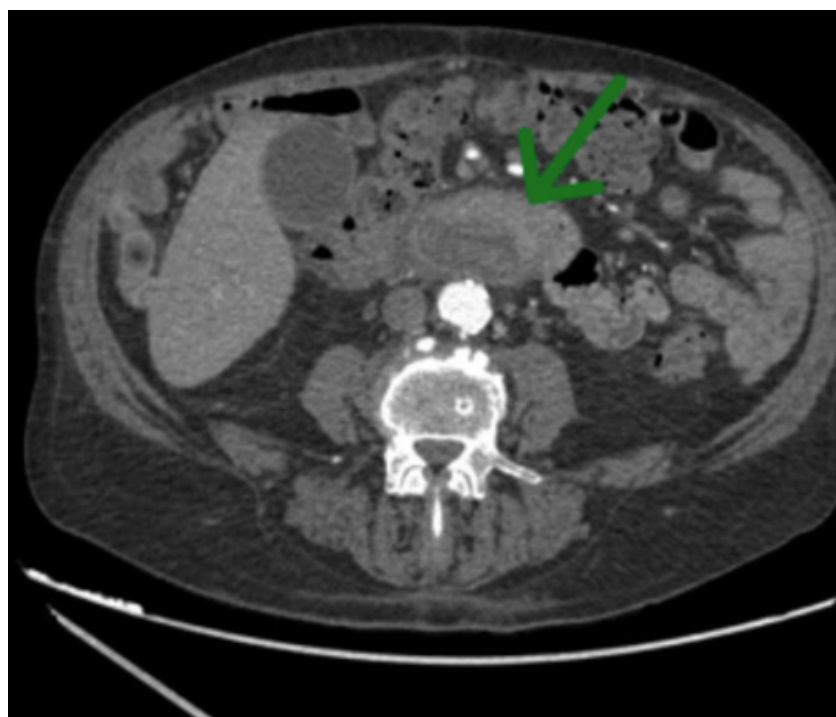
Abdominal CT: solid-necrotic duodenal mass
